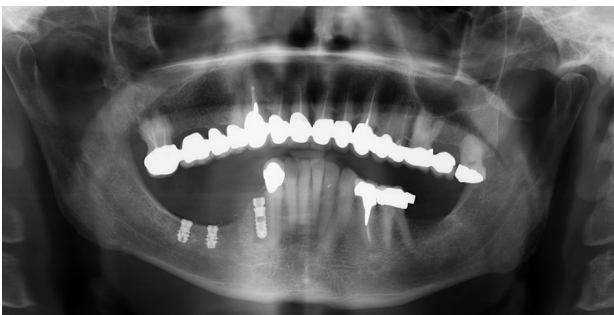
Post-Operative X-ray control showing perfect implant placement as planned with absolute Inferior Alveolar Nerve respect*
